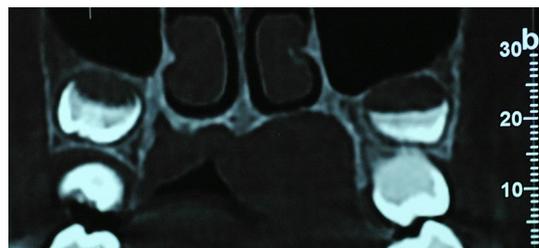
CBCT-coronal view. Thinning of the cortical palatal bone underlying the tumor
